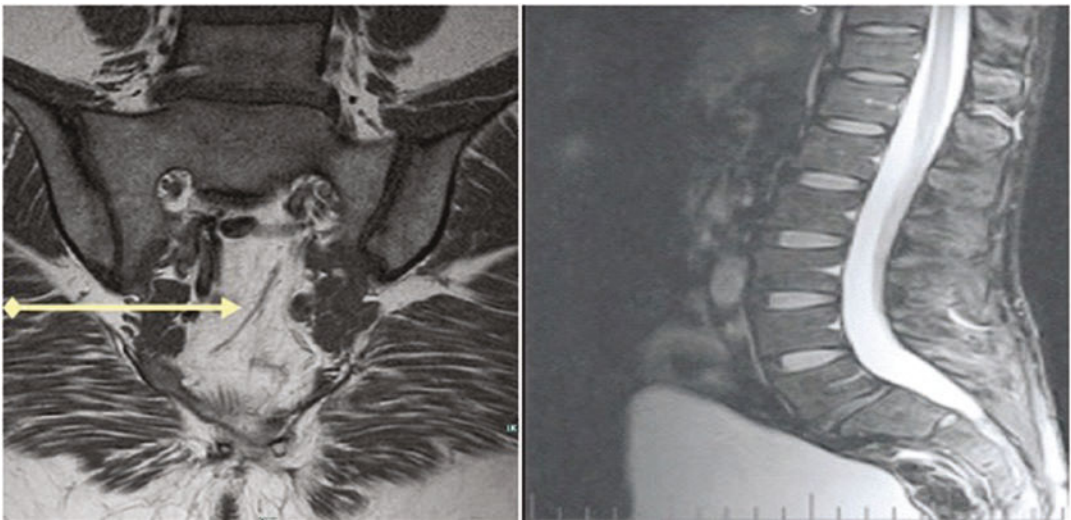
(a, b) A pre-op MRI of a patient that was not a candidate for the trans-sacral approach. (a) A midline pre-sacral vessel; (b) Significant amount of pre-sacral scarring
